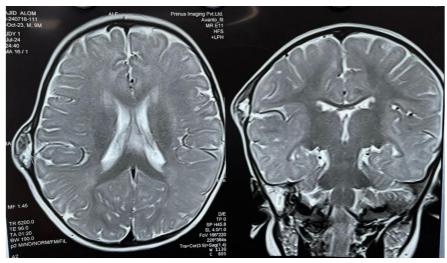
Pre-operative MRI films showing the swelling.
